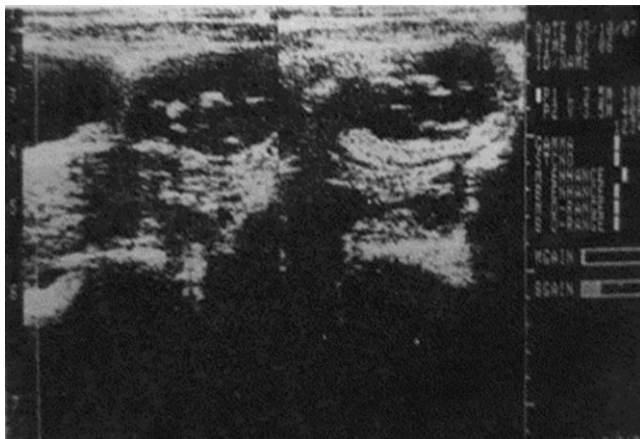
e. Sonograms (Trans.) of adnexal mass showing an oval sonolucent appearance, containing short thick internal echoes. The wall posterior is in layers from omentum and collapsed bowel walls.
